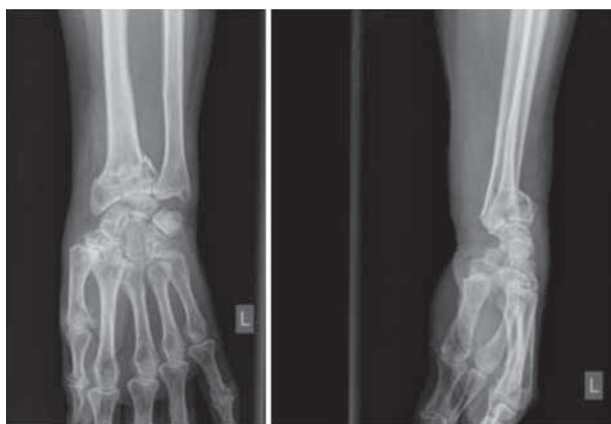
Case 1 (IA), x-ray distal radius AP and lateral view, female 73 y.
